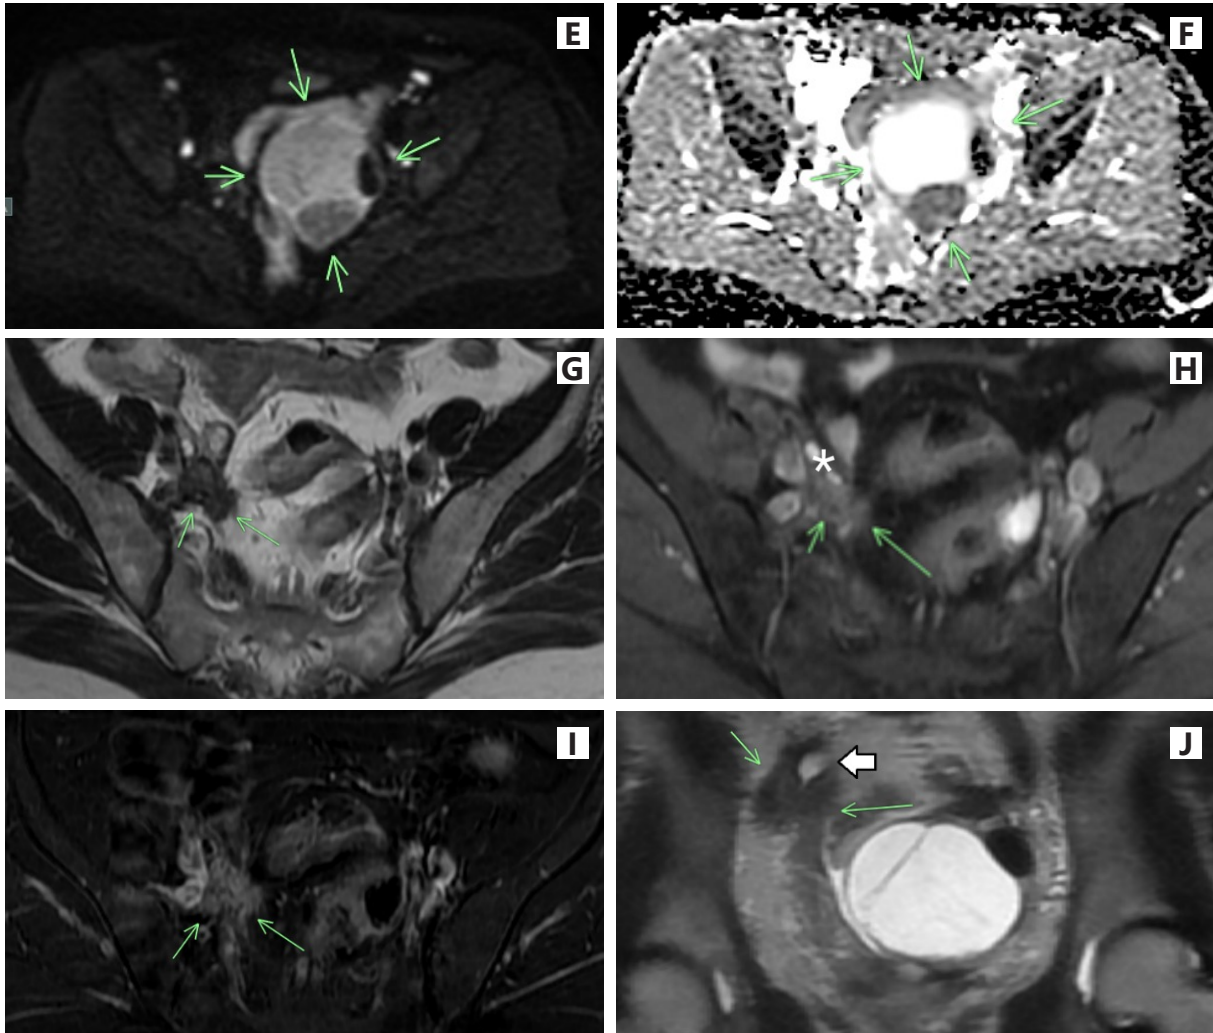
A 1.5 Tesla MRI scan of the pelvic cavity revealed a complex solid-cystic mass with dark signal intensity (SI) on T2-weighted imaging (T2WI) of the solid component (A). Signal voids were observed within portions of the solid component on the gradient-echo (GRE) image (arrow in (B)). The T1-weighted fat saturation (T1FS) image demonstrated areas of hyperintense signal within the mass. A focal enhancing solid component was identified on post-contrast images (asterisk in (D)); however, there was no evidence of restricted diffusion on diffusion-weighted imaging (DWI, $b=800$) (E) or on the apparent diffusion coefficient (ADC) map (F). An additional irregular, spiculated, heterogeneous lesion demonstrated intermediate-to-low SI on the T2W image (G) and intermediate SI on the T1FS image, with foci of high signal intensity on the T1FS image suggestive of hemorrhagic components (asterisk in (H)). This lesion showed minimal enhancement on the post-contrast T1FS subtraction image (I), with evidence of right distal ureter involvement on the coronal T2W image (J).
